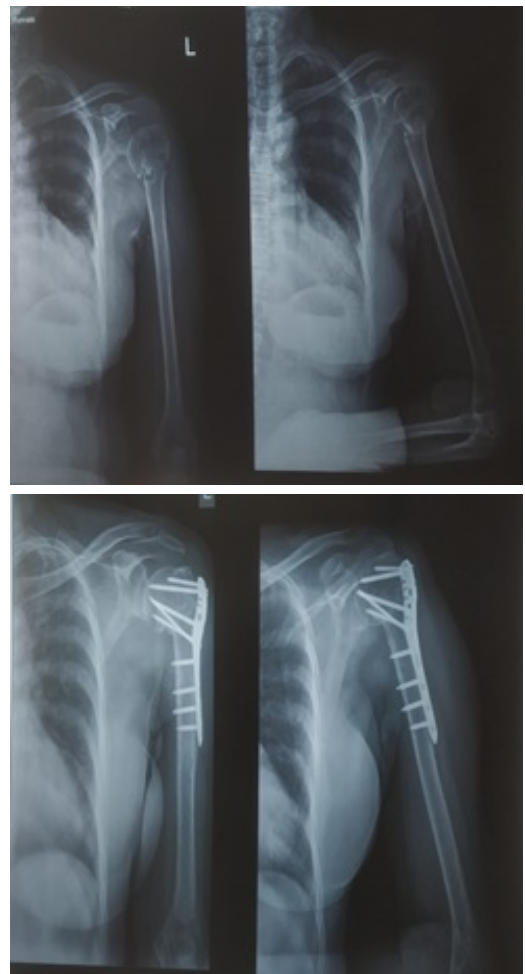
Patient 2 Pre-Operative X-Ray, Patient 2 Post-operative 6 months.
